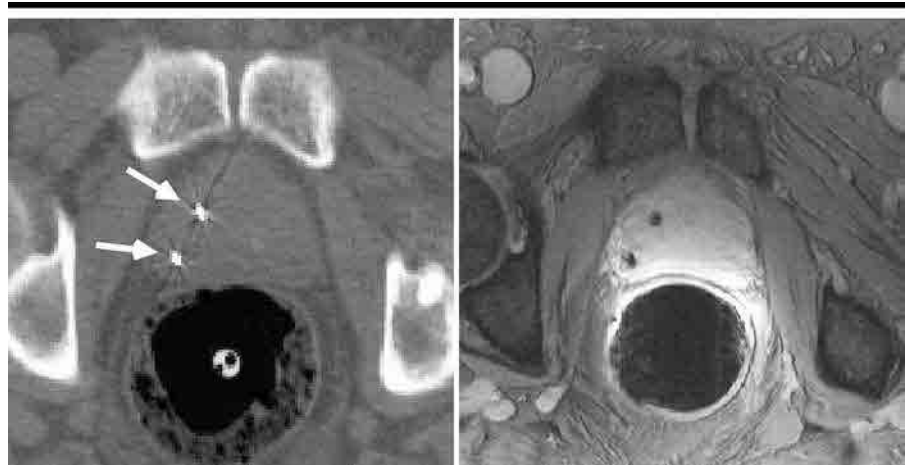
Transverse CT (left) and T2*-weighted MR (right) images (see Table 1 for MR imaging parameters) before image registration. Markers appear as bright spots at CT (arrows) and as dark spots at MR imaging.
